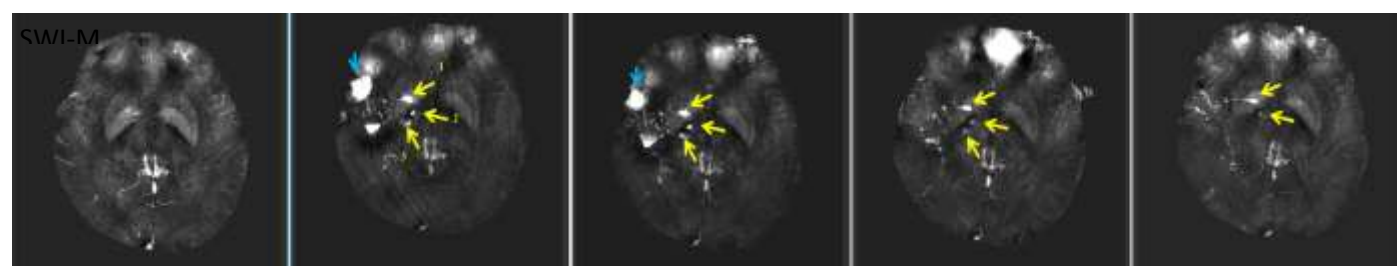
Magnetic resonance images of NSC injection sites that initially contained approximately 5 million USPIO-labeled NSCs each. Serial images of 1 patient demonstrate a gradual decrease in the size of signal density during the 31-day period after intracranial administration of USPIO-labeled NSCs. To facilitate visualization of Feraheme at the injection sites over time, a maximum intensity projection was performed across five individual SWI slice images. Yellow arrows point to 3 NSC injection sites that decrease in intensity over time, indicating migration of viable NSCs away from injection sites. Blue arrow indicates air bubble resolving over time. A) SWI images; B) SWI-M: quantitative mapping of images in A.
